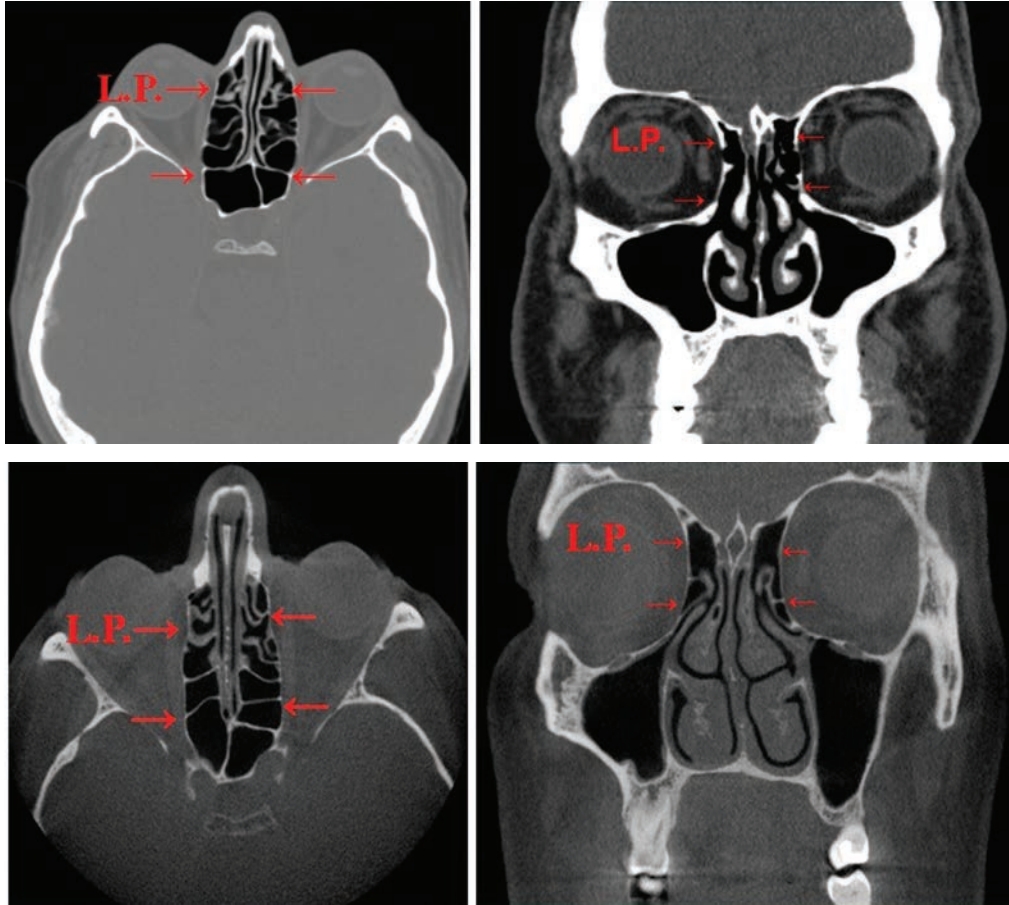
Axial and coronal sections of standart-CT (left) and CBCT (right) views of lamina papyracea
